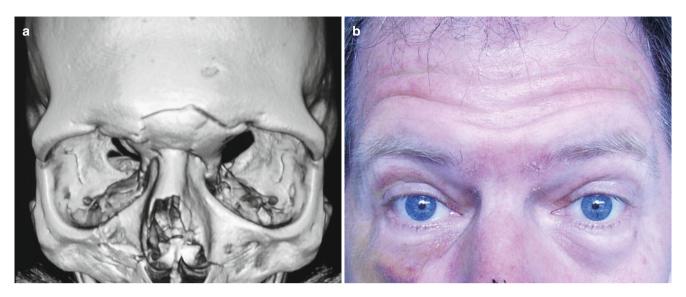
Three-dimensional CT demonstrates a localised depression in the anterior wall. This has resulted in a significant deformity which the patient requested be repaired. The presence of obvious skin creases made this fracture amenable for a transcutaneous repair (a, b)
